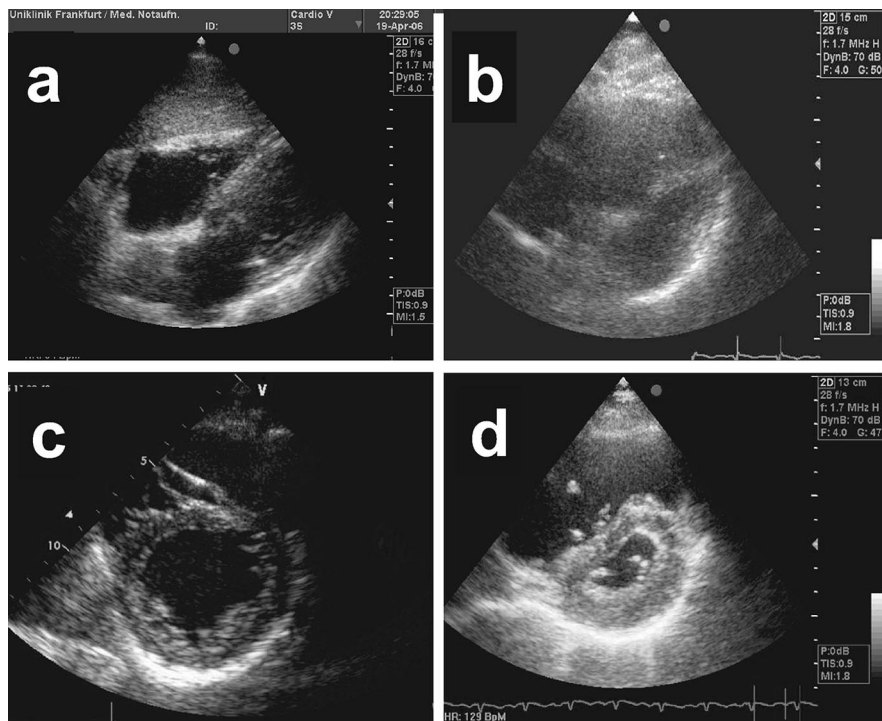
B-mode echocardiogram in acute right heart failure due to pulmonary artery embolism. Subcostal window, long axis, normal finding (a); enlarged right ventricle that can quickly be identified (b); parasternal, short axis, normal finding (c); paradoxical septal movement “D-sign” with impression of the left ventricle due to increased right ventricular pressure (d).
